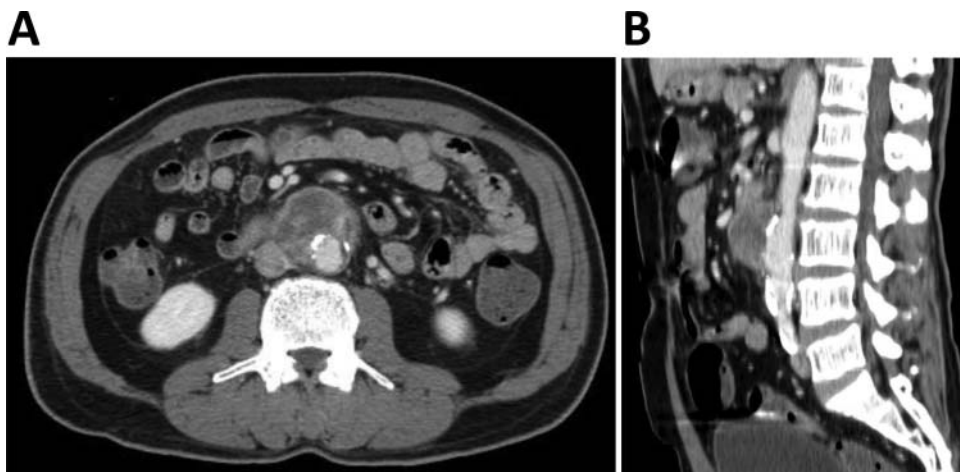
Abdominal CT scan showing a 46–143 mm diameter infrarenal abdominal mycotic aortic aneurysm with signs of cracking and infiltration of retroperitoneal fat.
